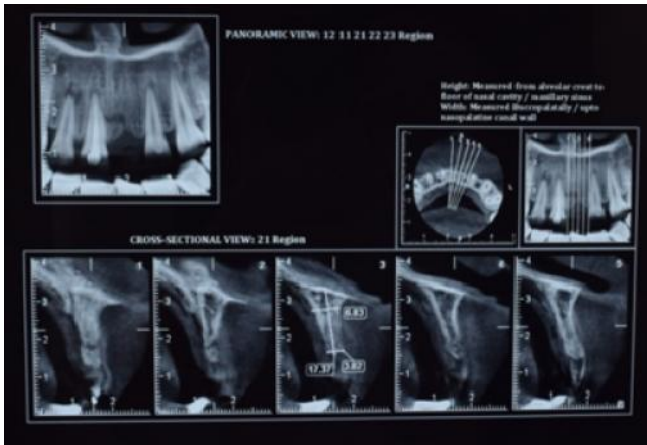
CBCT scan showing missing tooth and bone defect
